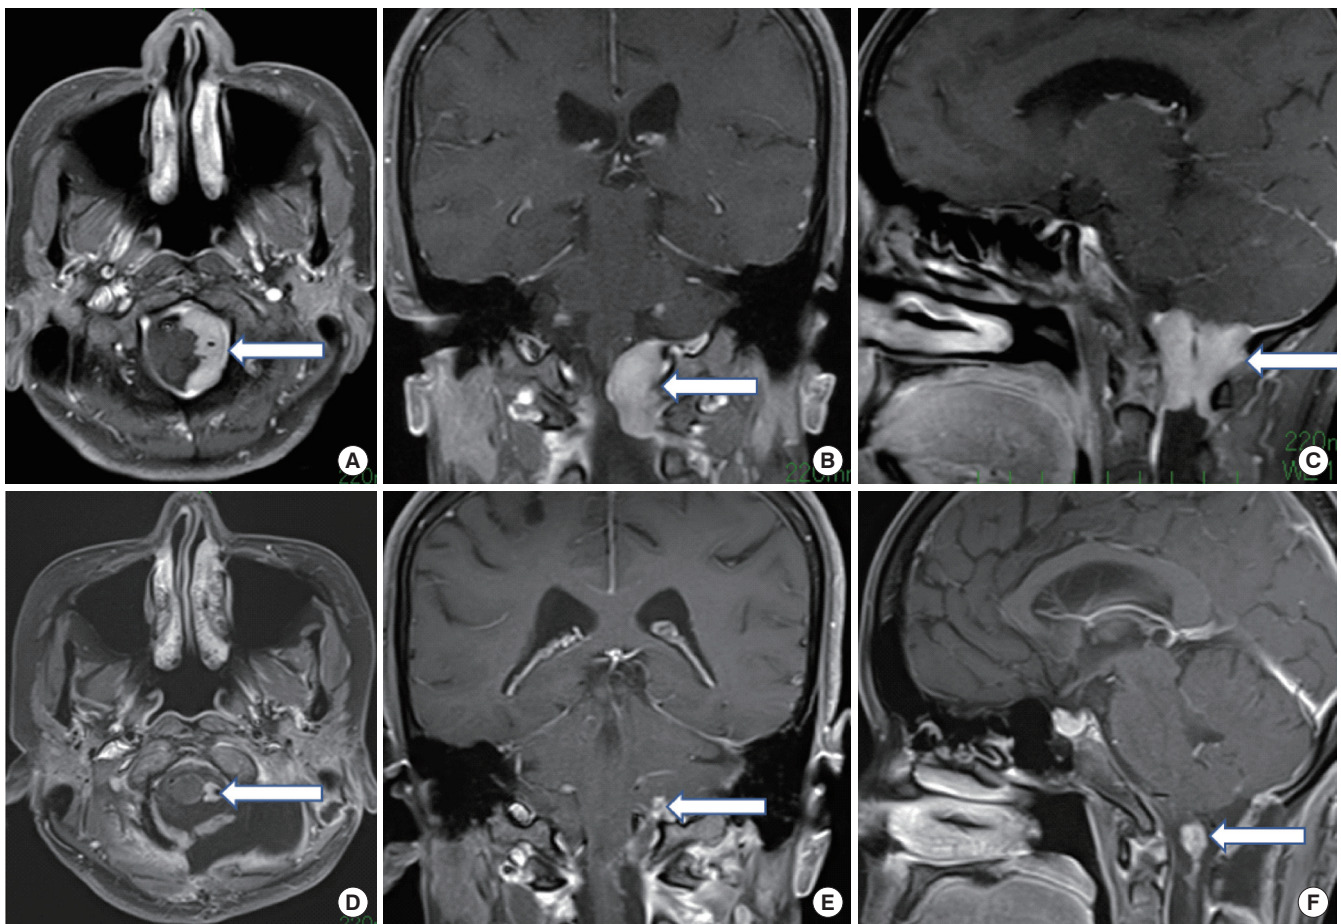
(A-C) Preoperative magnetic resonance (MR) images of patient with isolated intradural extramedullary tuberculoma showing homogeneously enhanced mass and dural-tail sign and significantly compressing the upper cervical cord (arrows). (D-F) Postoperative MR images of the patient showing residual mass (arrows) strongly adhered to the vertebral artery and posterior spinal arteries.
